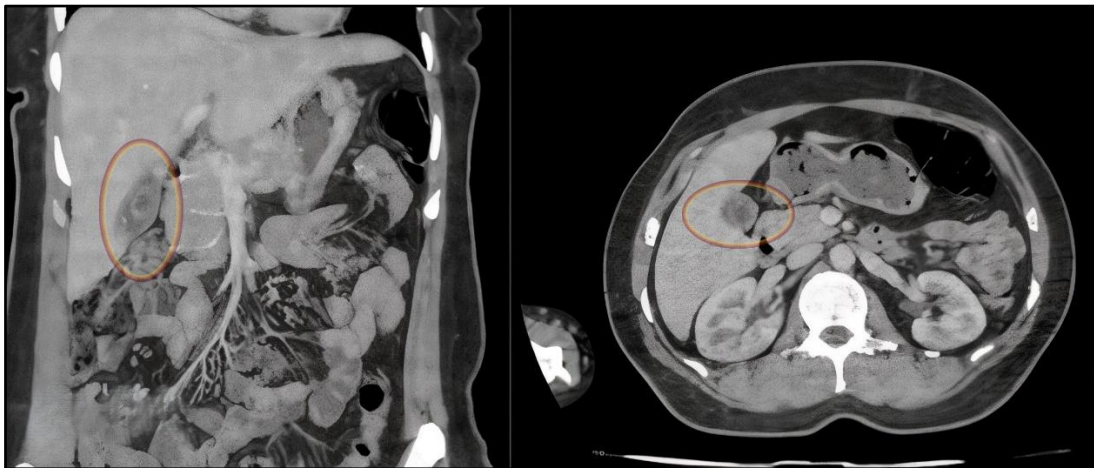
Computed tomography performed upon the patient's arrival in the Emergency Department for acute abdominal pain and discomfort revealed minimal gallbladder wall thickening and luminal gallstones.
